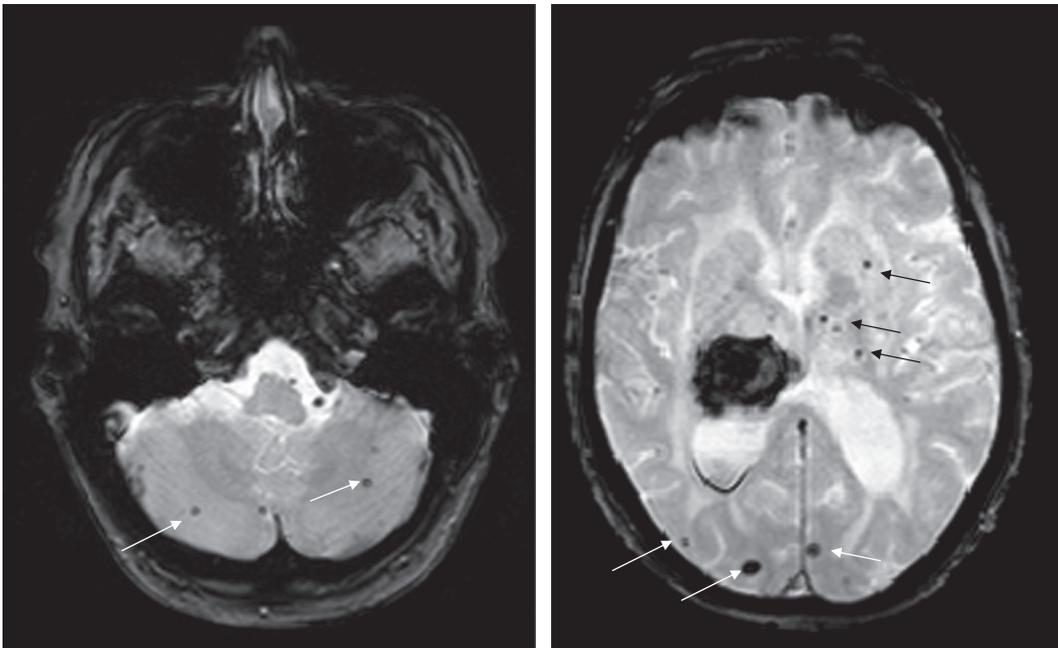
Microbleeds on MRI axial gradient-echo T2*. Left: brain microbleeds in the cerebellum (arrows). Right: brain microbleeds in deep and subcortical locations (arrows) and an intracerebral hemorrhage in the left thalamus and internal capsule. Courtesy of Charlotte Cordonnier, Lille.
